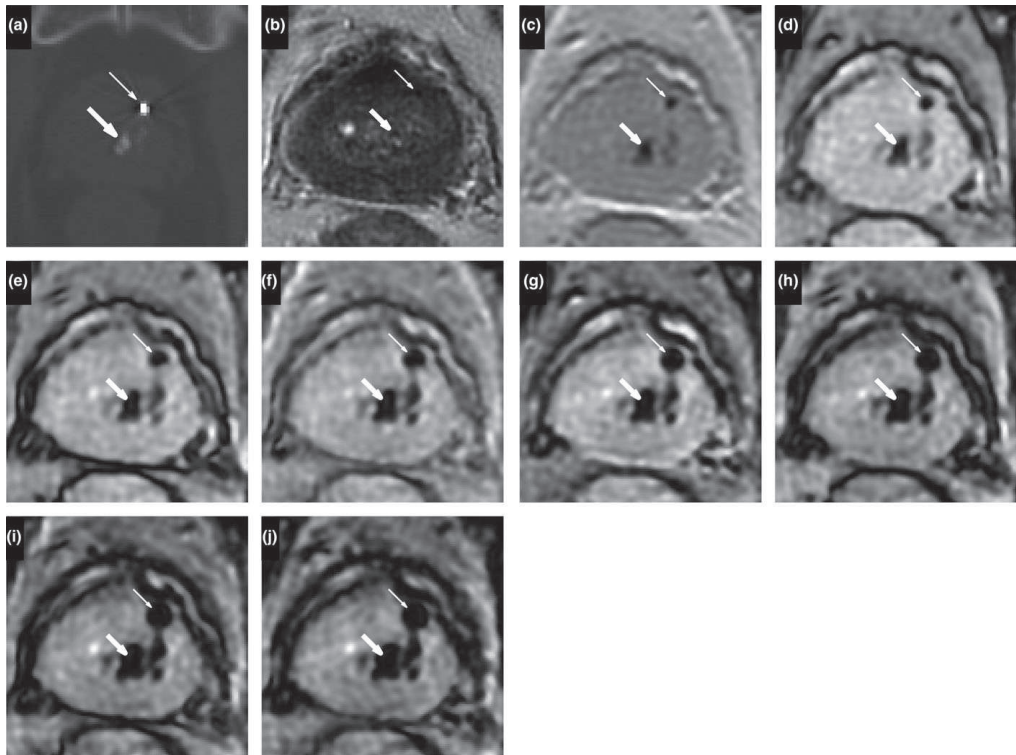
An example of challenging differentiation between gold fiducial markers (GFMs) and intraprostatic calcifications. A GFM and an intraprostatic calcification are shown in the figures as thinner and bold arrows, respectively. The images depict the visualization of the objects using (a) CT, (b) MRI T2w PROPELLER, (c–j) MRI MEGRE for increasing echo times in the span 2.38–23.6 ms with an inter echo time of 3.03 ms. The GFM creates a round signal void with increasing area in the MEGRE images.
